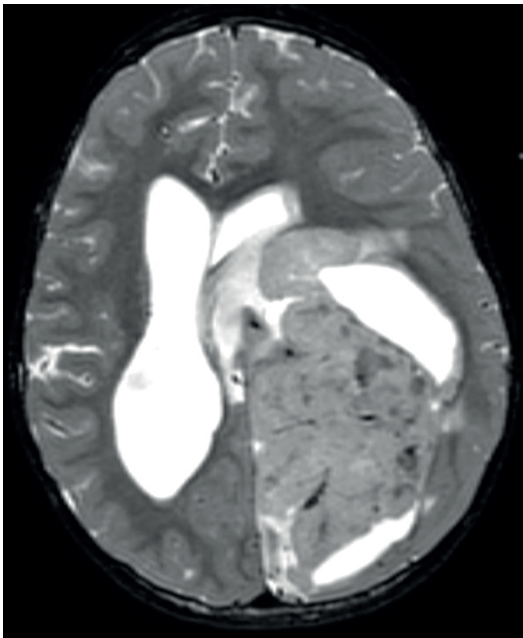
Magnetic resonance imaging of a CNS neuroblastoma, *FOXR2*-activated.
